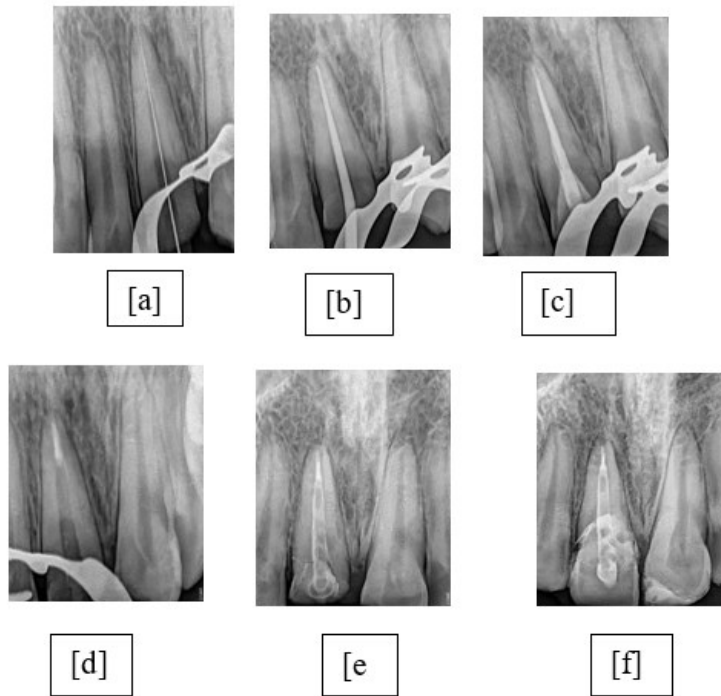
X-ray showing-[a] Working length [b] Master cone [c] Obturation [d] Apical Gutta percha [e] Post placement [f] Fragment reattached
